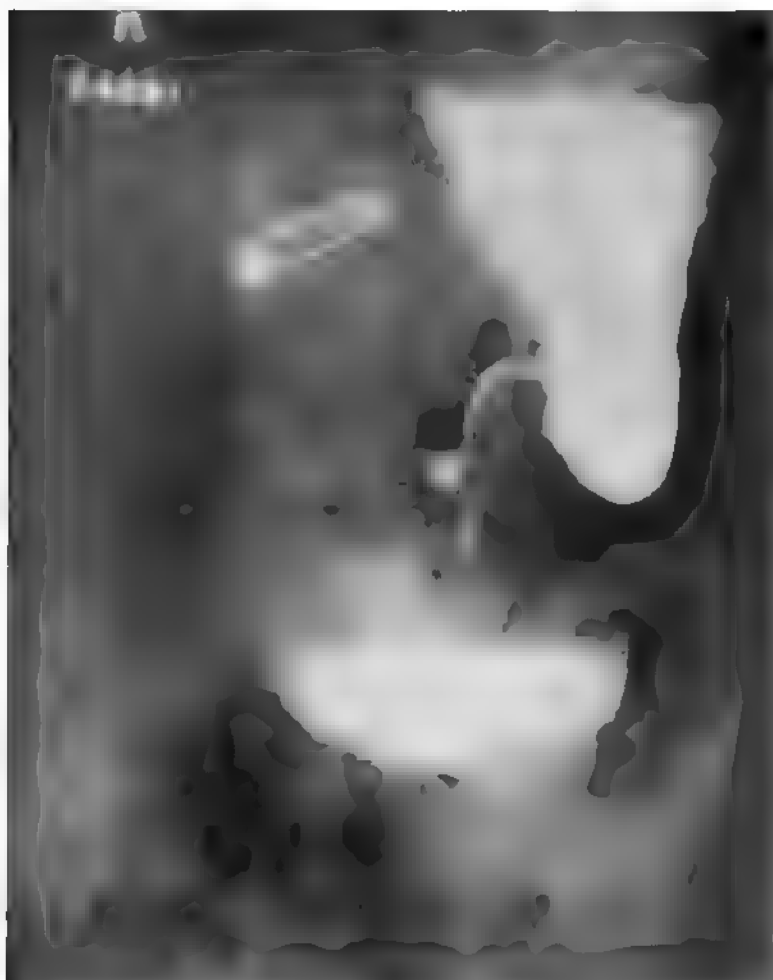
Case No. A69,922; X-ray No. 23,831. Penetrating ulcer with diverticulum. Hour-glass stomach.
